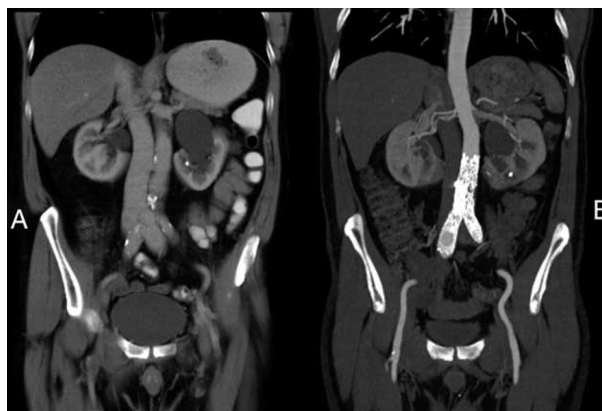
A, Abdominal CT scan revealing contrast in the vena cava during the arterial phase. B, Contrast in the vena cava during the arterial phase was no longer apparent after endovascular repair.
